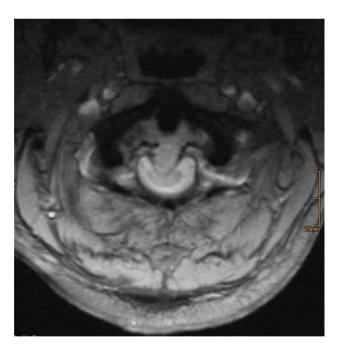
Preoperative T2-weighted axial magnetic resonance spin-echo showing an inhomogenous smooth mass stretching over about half of the spinal canal and compressing the cervical spinal cord
